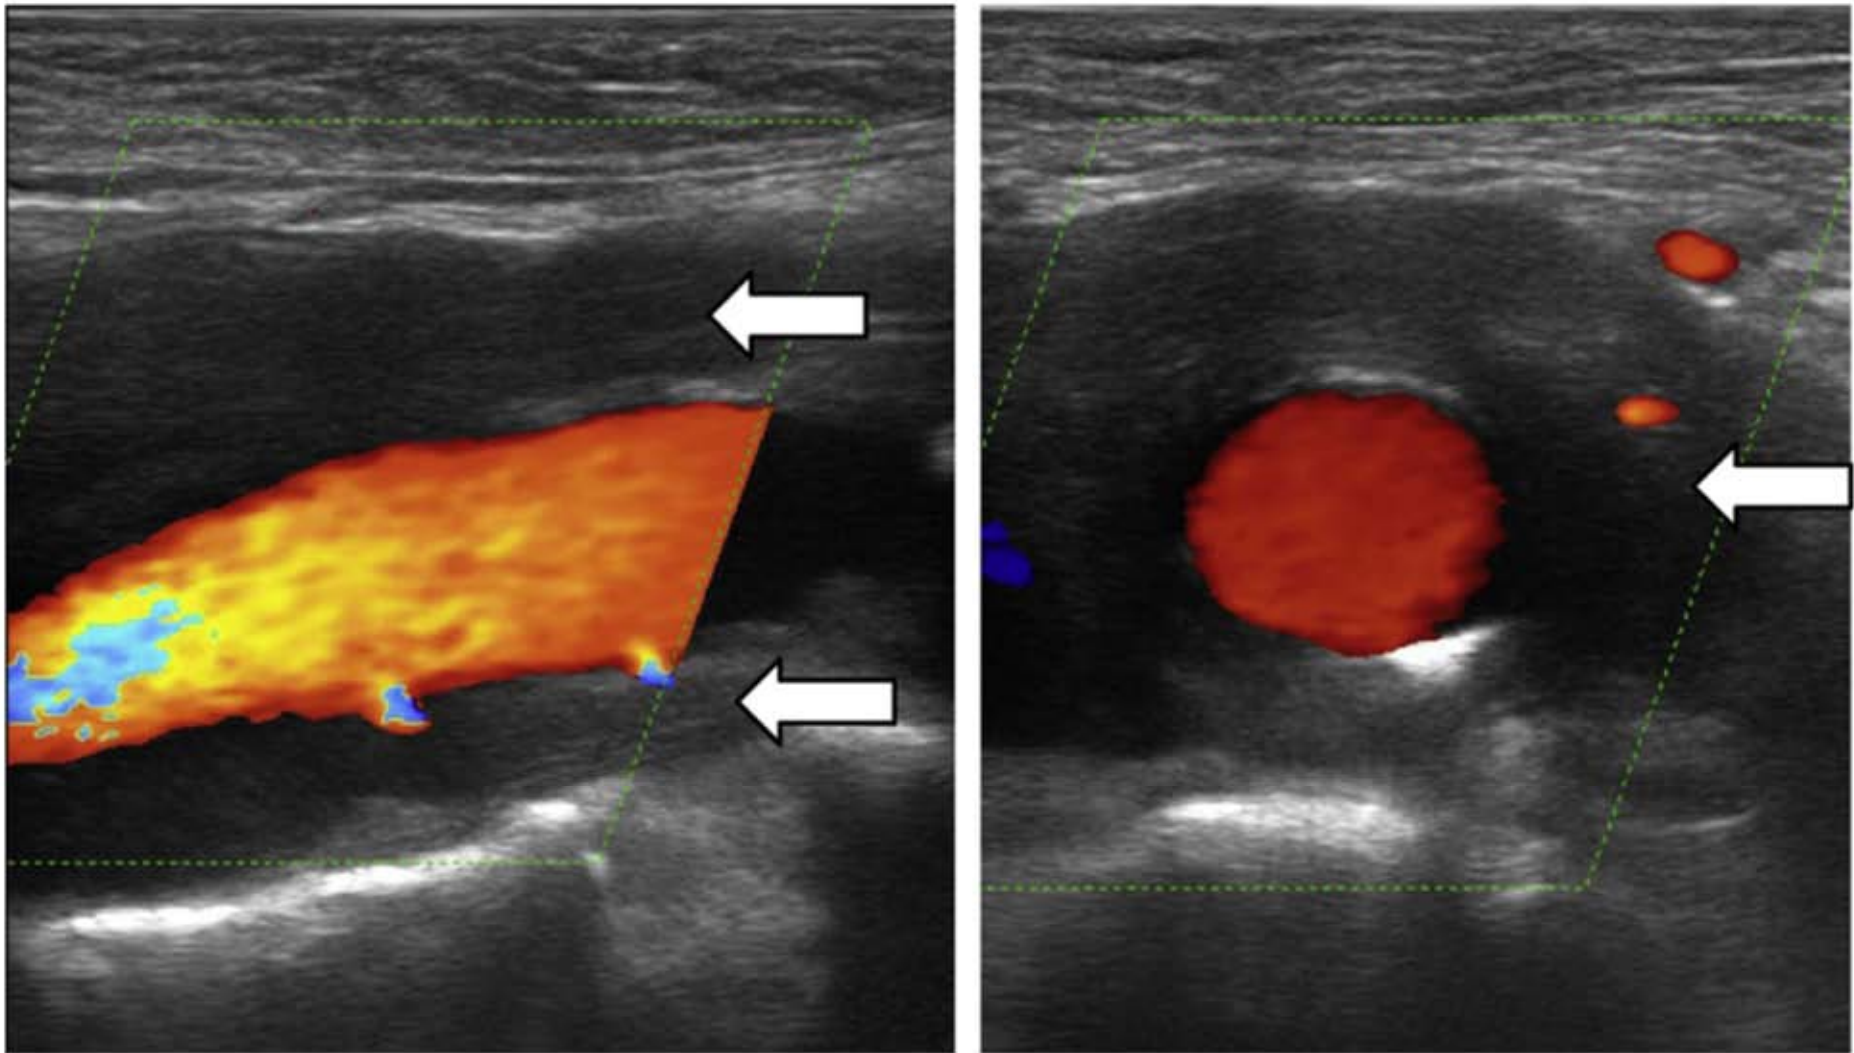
Longitudinal (A) and transverse colour Doppler ultrasound images of abdominal aortitis. The arrows indicate the vasculitic wall swelling. The patient presented with pyrexia of unknown origin.
